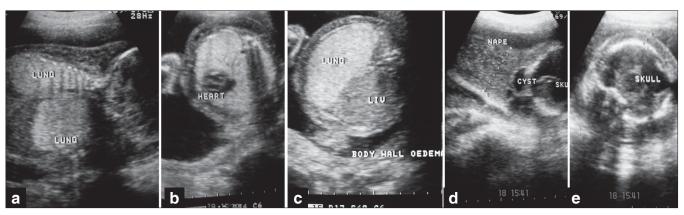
(a) Sonography showing bilateral large hyperechogenic lungs with flat/inversion diaphragm, (b) Sonography showing compressed small anteriorly displaced non-functioning heart due to enlarged lungs, (c) Sonography revealing fluid in body wall, (d) Sonography revealing fluid in nape of neck, (e) Sonography revealing fluid skull edema with positive Spalding sign and areas of breakdown
